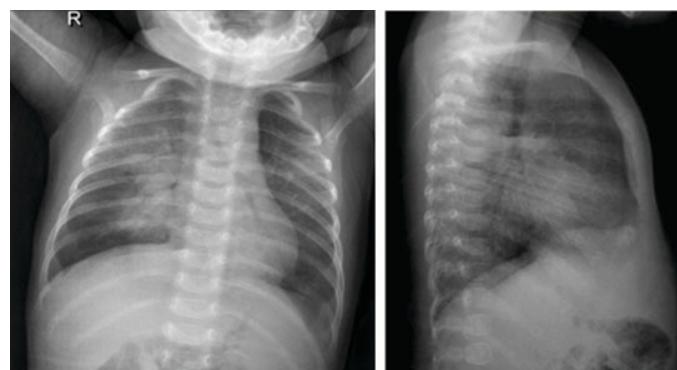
Chest X-ray on admission showing hyperaeration with bilateral pneumonia mostly on the right side.
